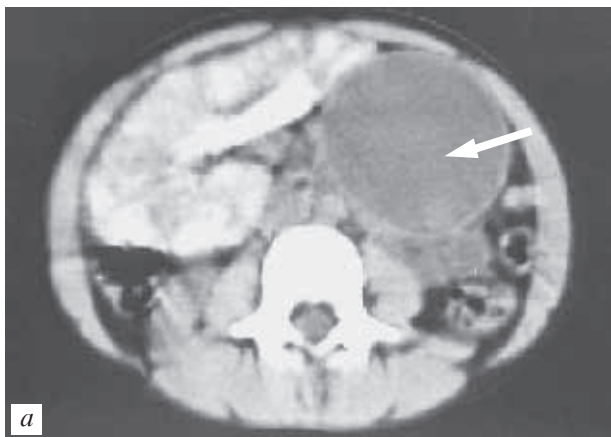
CT of teratoma of the left ovary (a, b)
